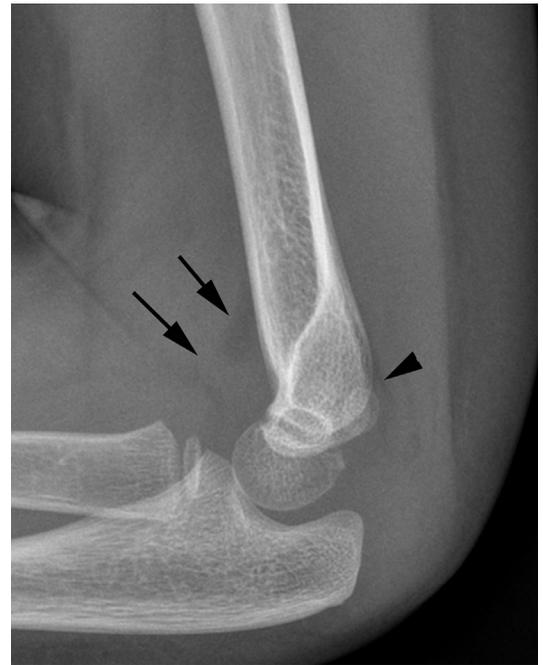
Lateral radiograph of the elbow in a 4-year-old girl after fall demonstrates elevation of the anterior fat pad (*arrows*) and posterior fat pad (*arrowhead*) indicating joint effusion.
